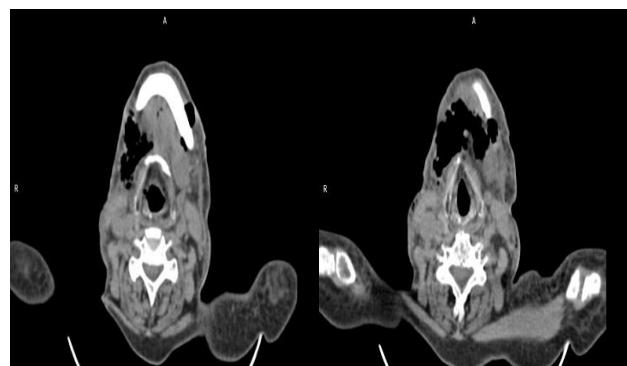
Computed tomography of neck with axial images showing pockets of collection with multiple airfoci noted in submandibular region.
